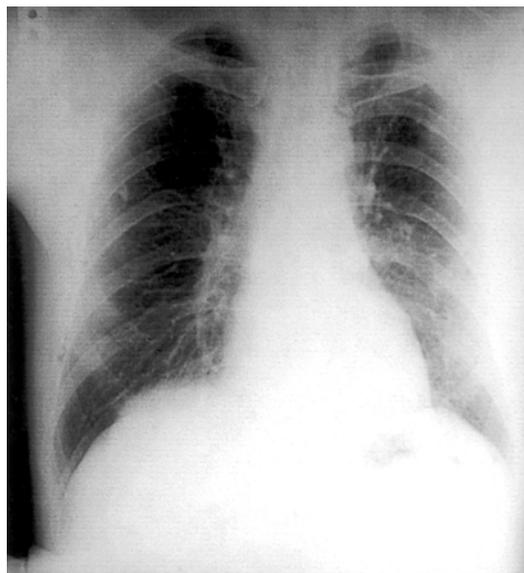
Twelve months later, the follow-up chest radiograph with the use of prednisolone revealed a marked-size reduction of the mass.
